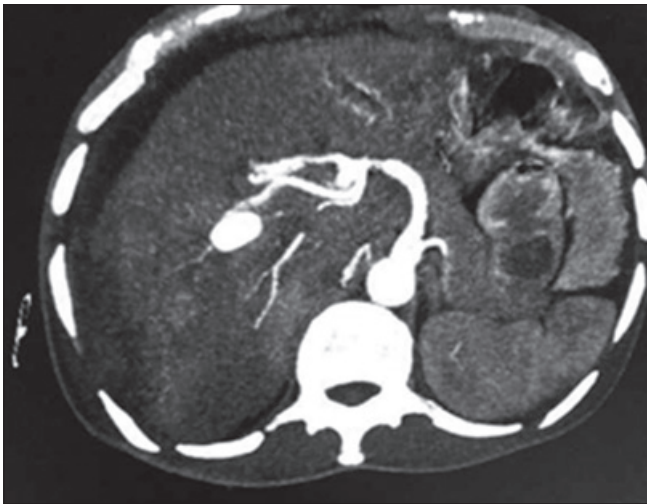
Axial CT MIP Image revealing a large pseudoaneurysm of right hepatic artery
